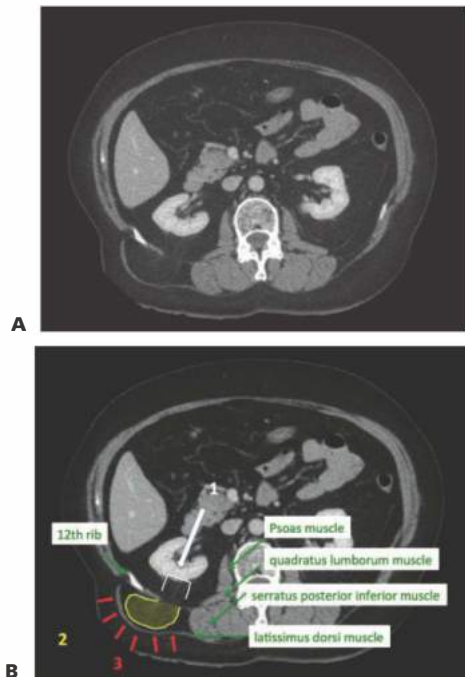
• A. CT of a patient with a right-sided lumbar hernia. The hernia defect is located lateral to the quadratus lumborum muscle. The hernia contains some retroperitoneal fat. The latissimus dorsi muscle covers the hernia sac. B. 1 (white) The hernia defect in the abdominal wall muscles just lateral to the quadratus lumborum muscle. 2 (yellow) The hernia sac with retroperitoneal fatty tissue. 3 (red) The intact latissimus dorsi muscle covers the hernia sac. Green arrows: the names of the different muscle involved.
